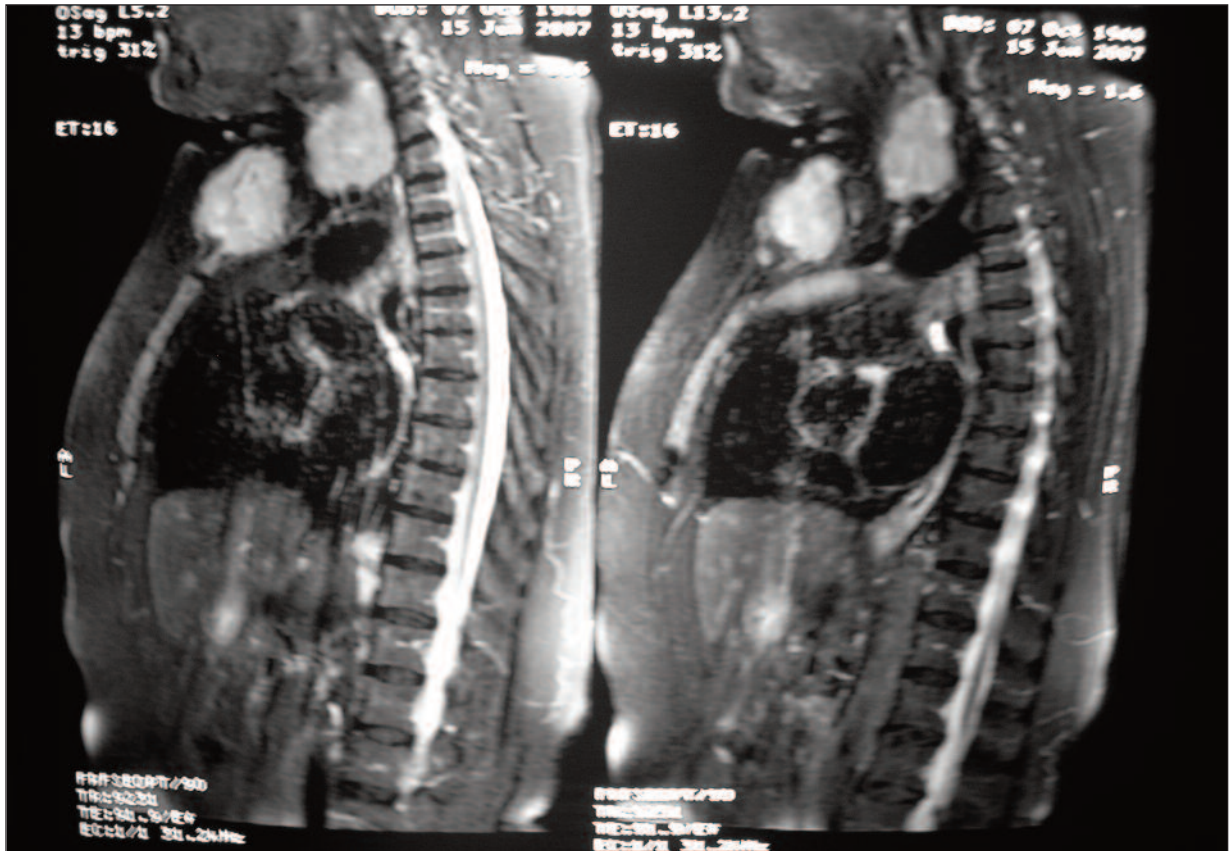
CT of sagittal section: Computed tomography scan of the neck and thorax showed soft tissue swelling with destruction of the underlying sternum.
